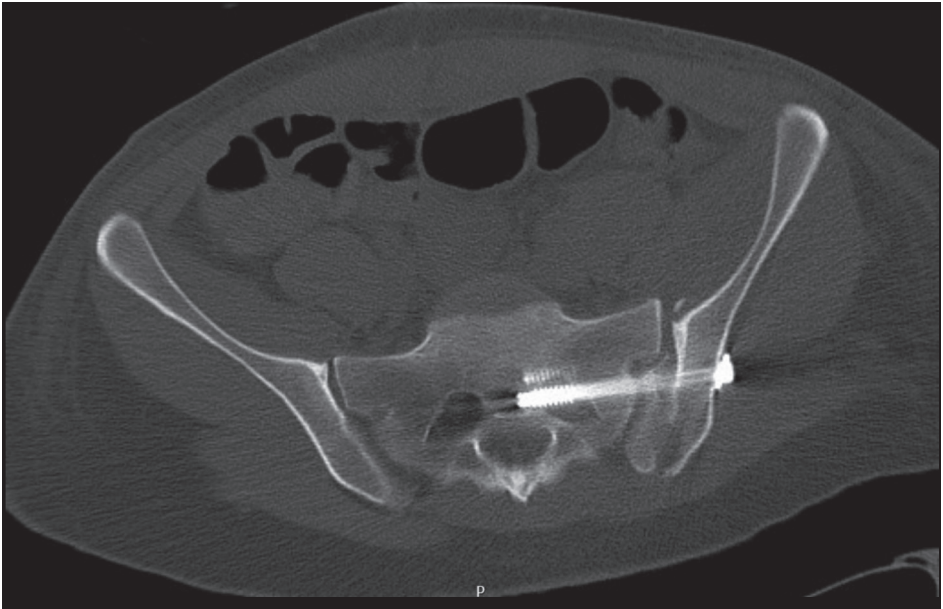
Placement of two SI screws displayed in a postoperative CT scan. The posterior SI screw is placed through the neuroforamina
